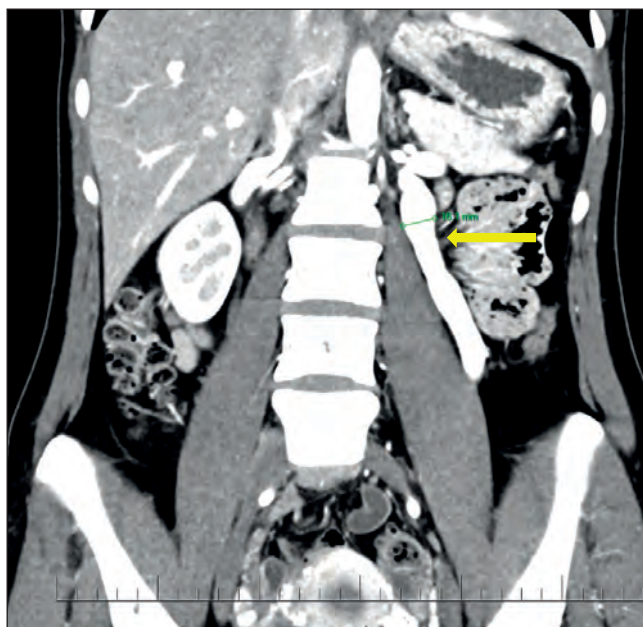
CT-venography findings of the left renal vein compression with diameter of dilated left ovarian vein = 16.1 mm (archive of the VUSCH).
